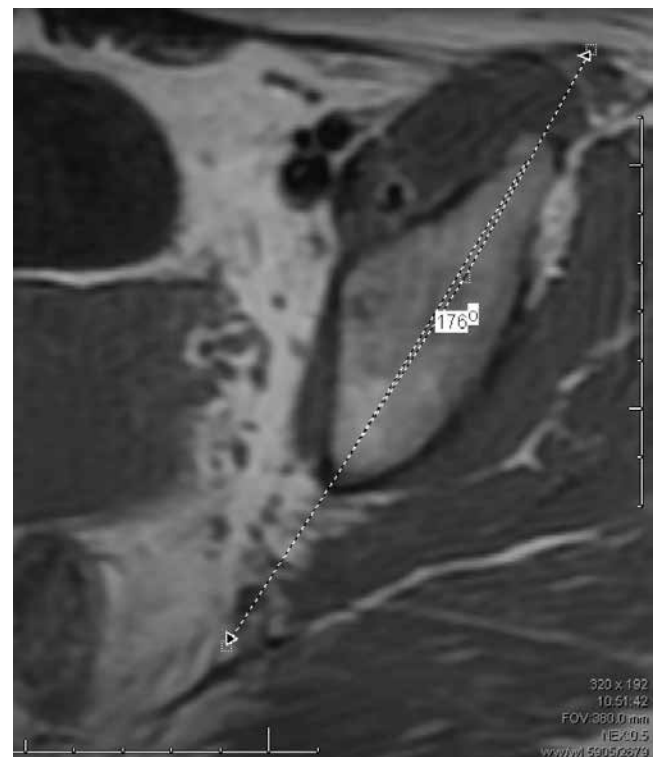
Measurement of the angle between the mid axis line of the ilium and the mid axis line of the anterior inferior iliac spine using MRI.
